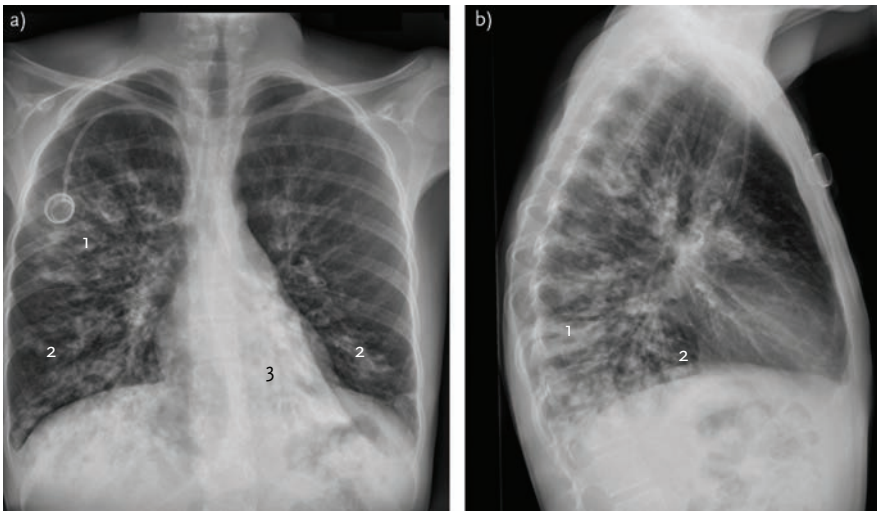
Chest radiograph of a 15-year-old female CF patient with advanced lung disease a) posteroanterior view and b) lateral view. The radiograph shows pronounced pulmonary hyperinflation with sternal bowing, bronchial wall thickening and bilateral bronchiectasis, infiltrates mainly in the right upper lobe (1) and in the lower lobes on both sides (2) as well as atelectasis of the left lower lobe (3). Note the central venous access (Port-a-Cath system; Smiths Medical, St Paul, MN, USA). Image courtesy of E. Stranzinger (Division of Radiology, University Children's Hospital of Bern, Bern, Switzerland).
